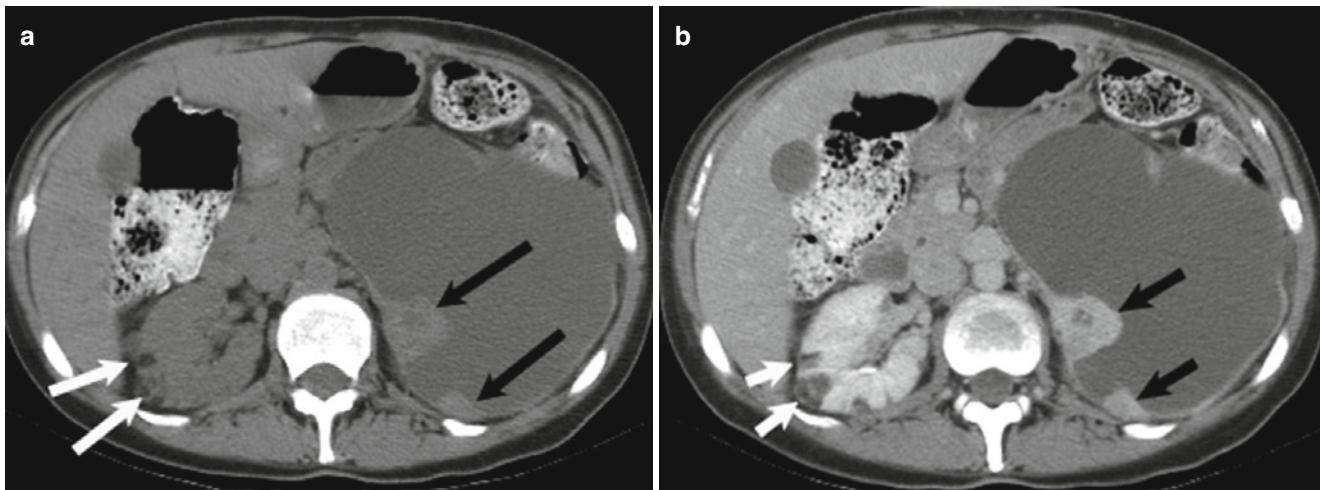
Cystic renal cell carcinoma. Axial unenhanced (a, b) contrast-enhanced CT images demonstrates a large cystic left renal mass with nodular enhancing components (*black arrows*). Enhancement
